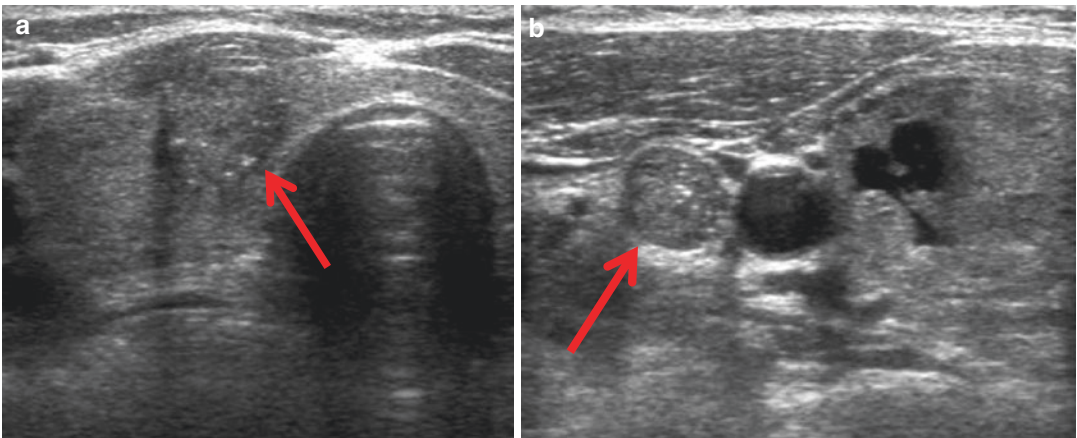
Red arrow indicates thyroid nodule (a) and lymph node (b) with ultrasound characteristics typical of papillary thyroid cancer
